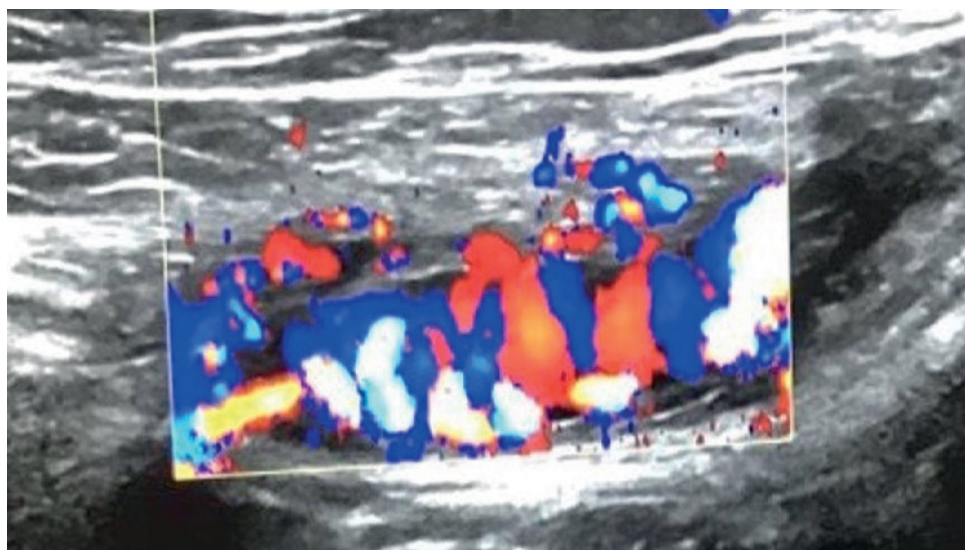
Doppler ultrasound scan longitudinal plane showing vascular structures in the right inguinal region with mainly venous blood flow (blue).
